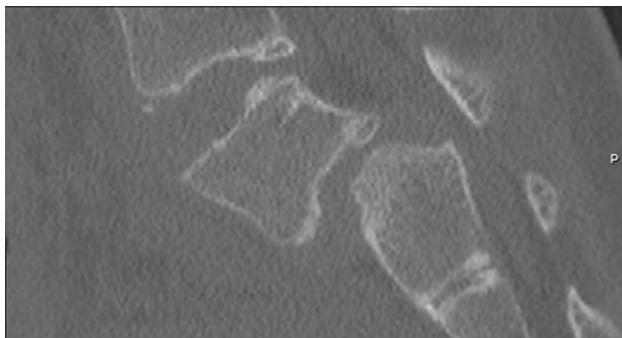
Sagittal CT imaging demonstrating Grade 3 Spondylolisthesis. Reproduced with permission from the Children's Orthopaedic Center, Los Angeles
